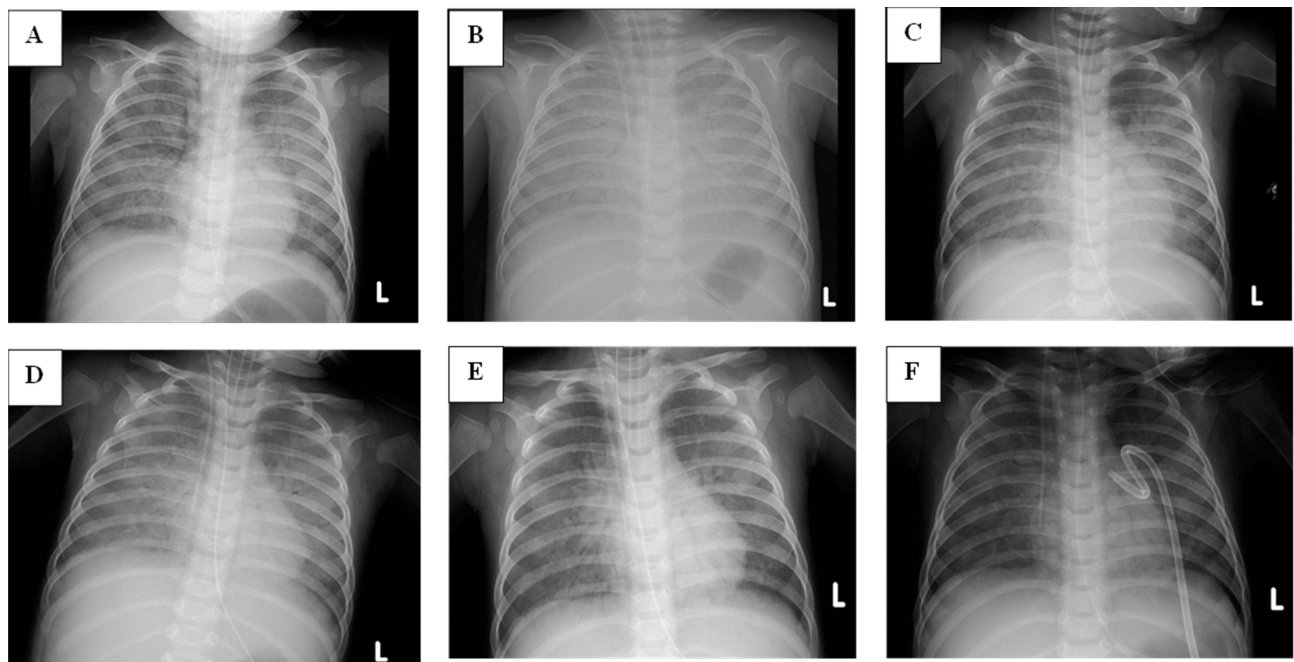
Posteroanterior Chest Digital Radiography (DR) of patient at different time-points during treatment (A: September 25), (B: September 28), (C: October 7), (D: October 19), (E: October 29) and (F: November 6).
